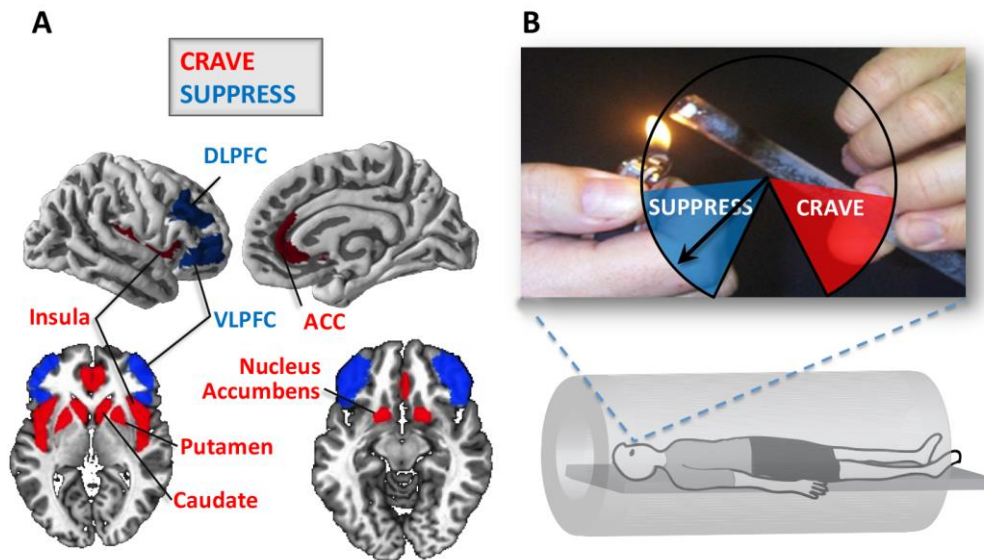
Real time neuroimaging as a technique to control craving developed in our lab. A. Regions involved in craving (red) include bilateral insula, putamen, caudate, nucleus accumbens, and anterior cingulate cortex (ACC). Regions involved in suppressing craving (blue) include dorsolateral prefrontal cortex (DLPFC) and ventrolateral prefrontal cortex (VLPFC). Not shown are areas that are implicated in both craving and suppression, such as medial orbital frontal cortex and bilateral amygdala. B. In ongoing studies in our laboratory, crack cocaine addicts are shown images of the drug and associated paraphernalia while in MRI. Participants are instructed to suppress their craving, and feedback representing the ratio of activities in the craving and suppression networks (panel A) is shown in the form of a meter on the screen. The end goal of this putative therapy is to strengthen cognitive control, fortifying participants with the capacity to overcome their craving when faced with enticing environmental drug cues.
